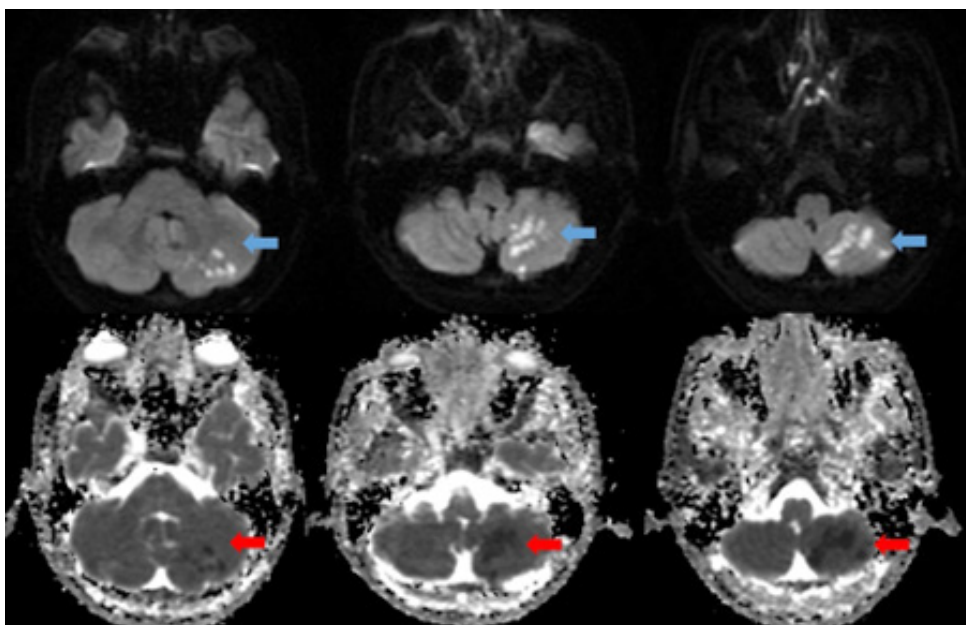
The acute infarct area in the left cerebellar hemisphere, is indicated by the arrow on the diffusion-weighted imaging (DWI) and Apparent diffusion coefficient (ADC) sequence in the diffusion MRI.
